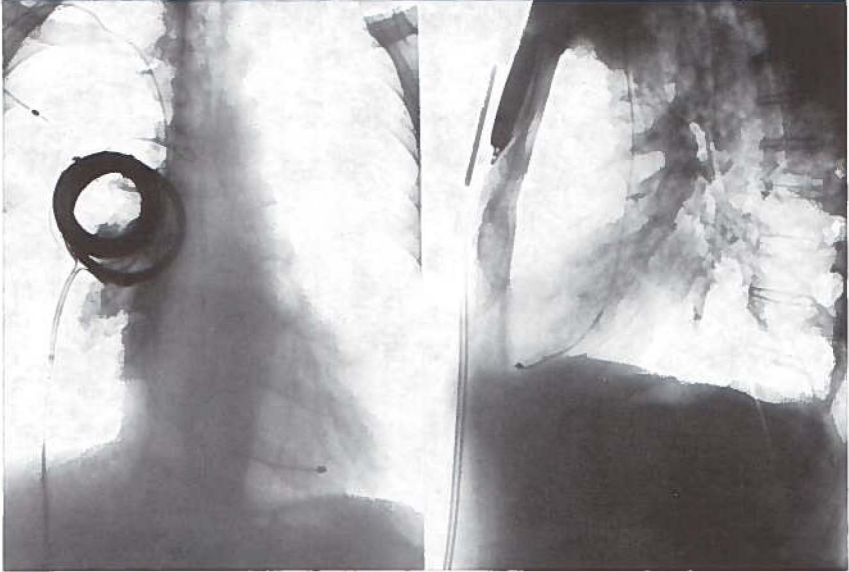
X-ray pictures of a patient stimulated with magnetic impulse transmission, showing external transmitter coil, internal receiver coil and monopolar catheter electrode. (By courtesy of DR. L. D. ABRAMS).
